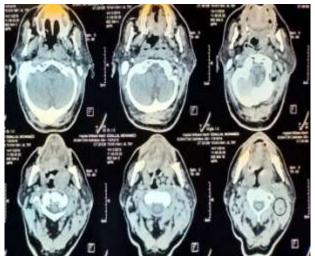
CT scan of the neck;
